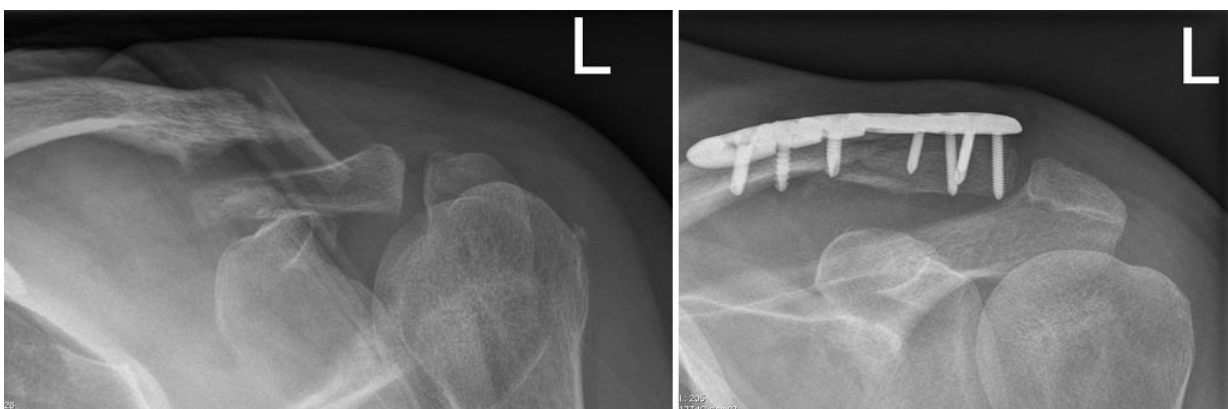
Preoperative radiograph of LCF and postoperative radiograph after SCPLE fixation.
